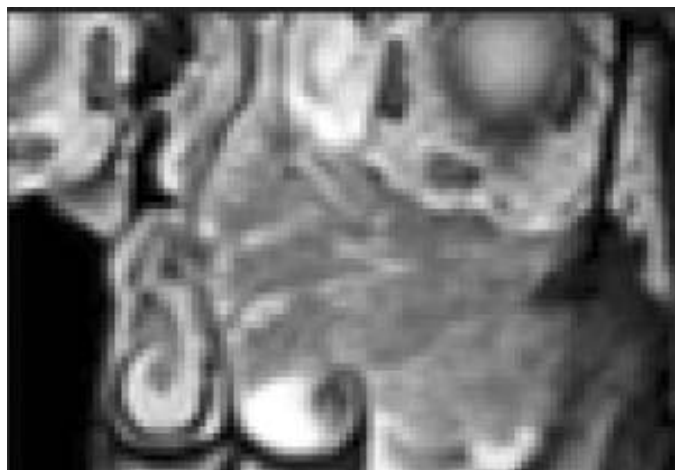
Characteristic MR imaging appearance of a CCP in IP. Coronal T2-weighted MR image showing alternating hypointense and hyperintense striations throughout the tumor involving the left maxillary sinus and nasal cavity.
